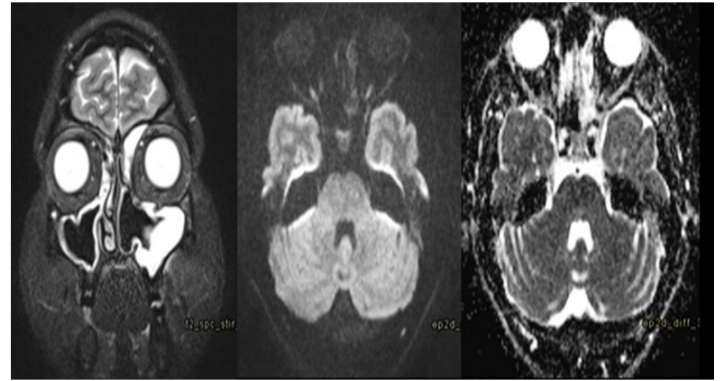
MRI T2 Stir Coronal, Axial Diffusion and ADC Images – MRI 3 months post FESS and radiotherapy revealed MRI revealed diffuse mucosal thickening to suggest chronic sinusitis on T2 Stir coronal image and no areas of fluid restriction to suggest absence residual tumour.
